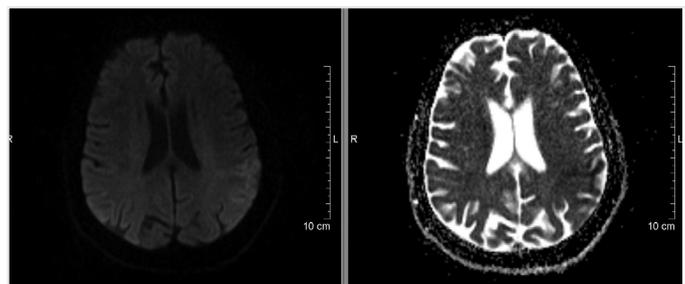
Left MCA infarct in cranial diffusion MRI (performed in the first hour)
